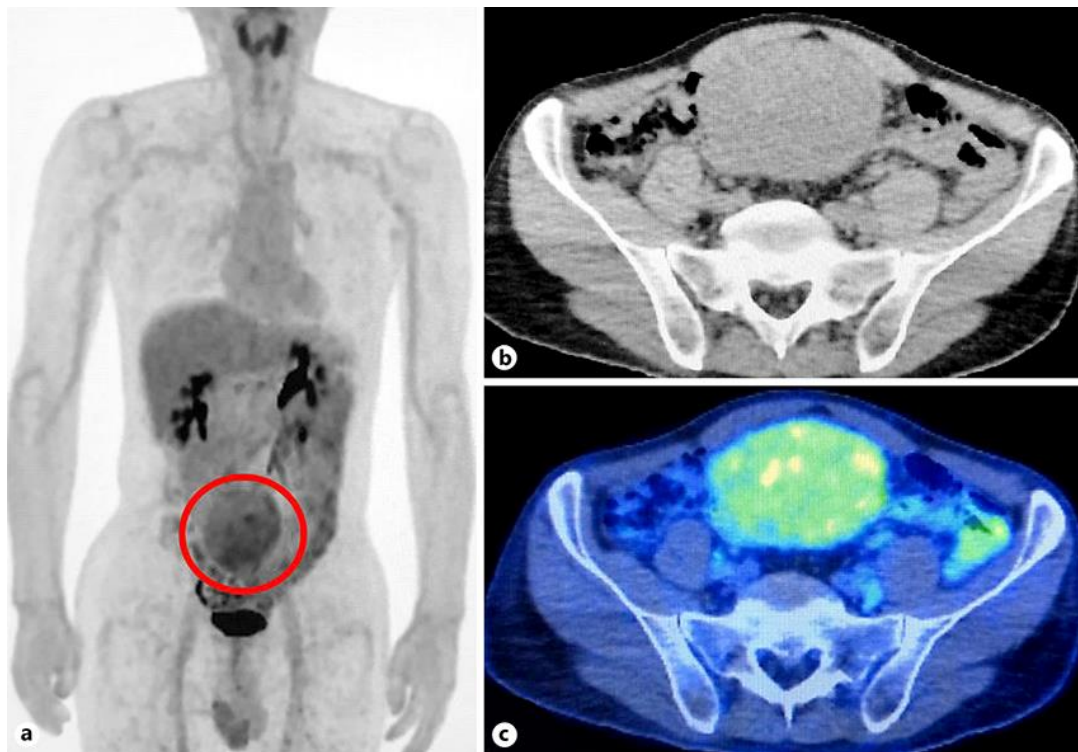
Positron emission tomography (PET) images. The tumor (circle) showed a heterogeneously enhanced uptake on the lesion ($SUV_{max} = 4.40$) in the pelvis. No significant findings indicating metastasis or any other lesions were observed. a Whole body scan. b, c Axial images.
